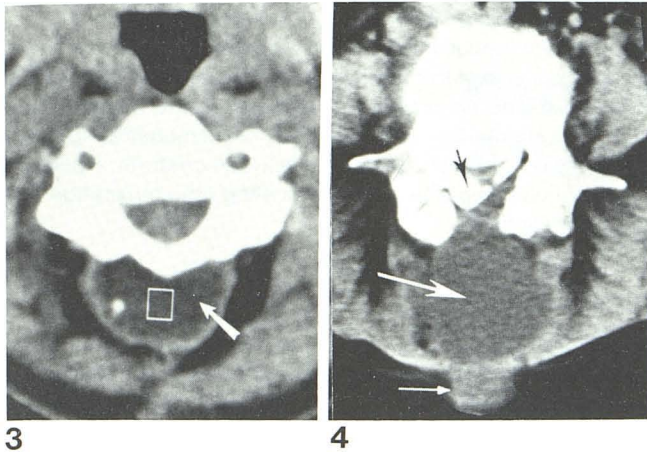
Cervical postlaminectomy pseudomeningocele. A neurofibroma was removed from C1–C2 months before. CT was performed because of recurrence of symptoms. A round, low-density area (*arrow*) is just behind bilateral laminectomy at C2. A droplet of Pantopaque from preoperative myelogram is within lesion. Distinct dense capsule is best seen where surrounded by fat. Lesion was spherical, about 3.0 × 2.5 cm.
